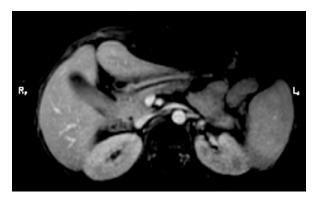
Magnetic resonance angiogram (post-contrast T1-weighted arterial time image, in axial view) shows an apparently normal left renal artery emerging from the aorta.
